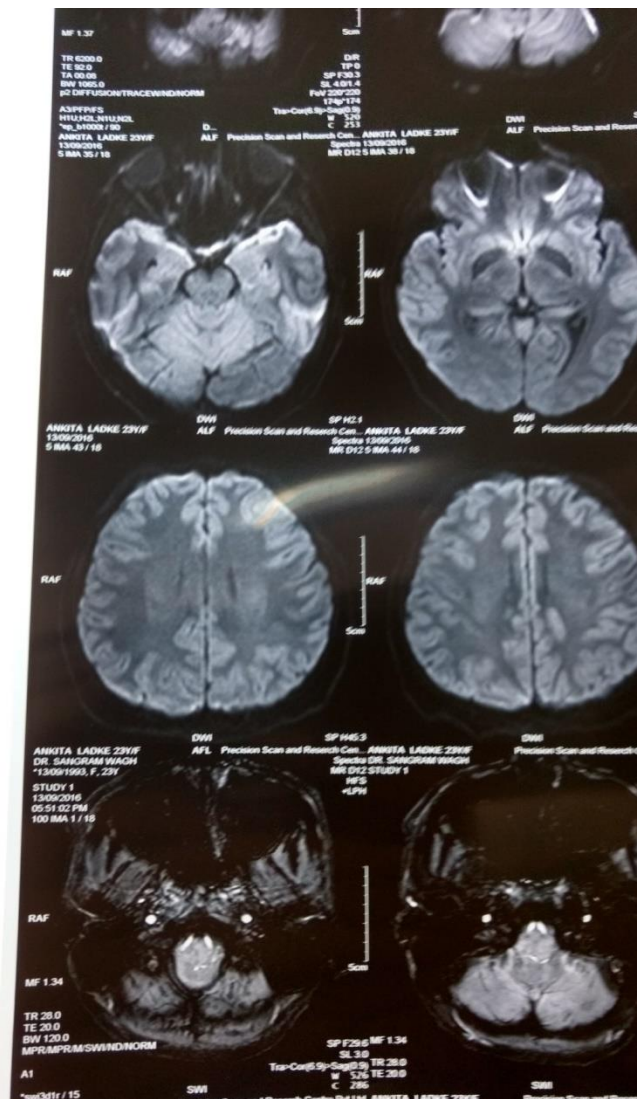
MRI brain s/o features of encephalitis.
